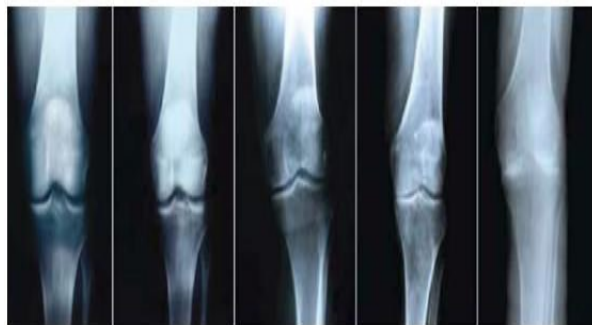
Plain radiograph of knee osteoarthritis grade
